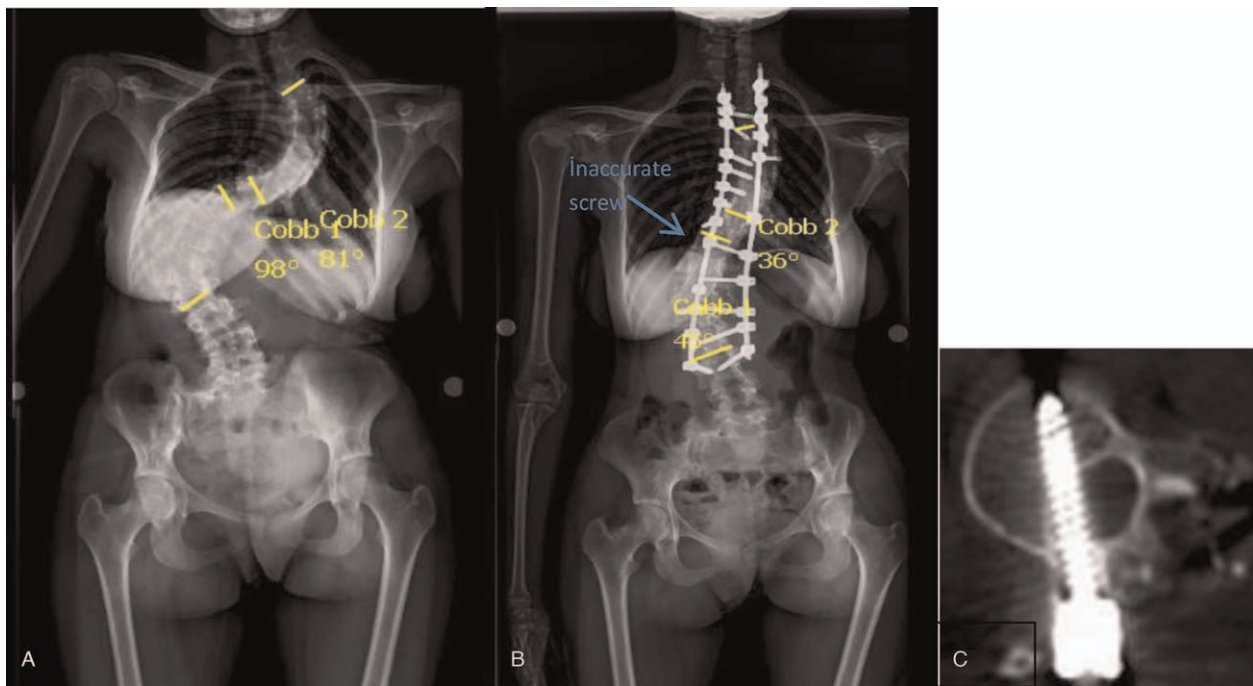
(A) A 15-year-old girl with idiopathic scoliosis Lenke type 3. (B) Postop. Cobb angle was proximal: 36, and distally: 45°. (C) The postoperative CT shows that T12 screw was abutting dura mater. Because the patient was asymptomatic, this screw was not removed. CT=computed tomography, T12=thoracic vertebrae 12.
